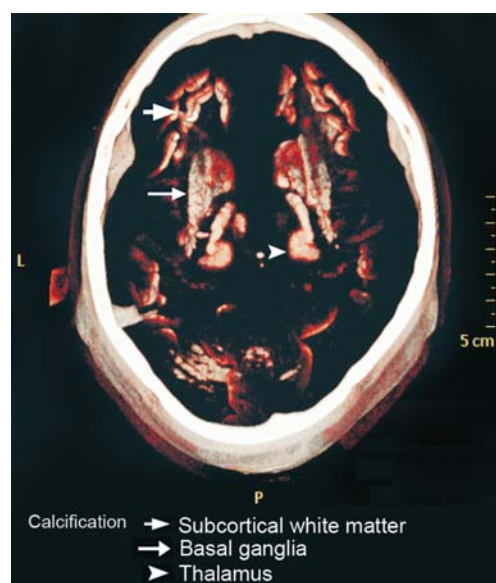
Volume rendered noncontrast-enhanced CT image, performed on 64 slice multidetector row scanner (Brilliance CT, Philips Medical systems, Cleveland, OH), revealed bilateral symmetric calcification involving basal ganglia, thalami, subcortical white matter, corona radiata and cerebellum
